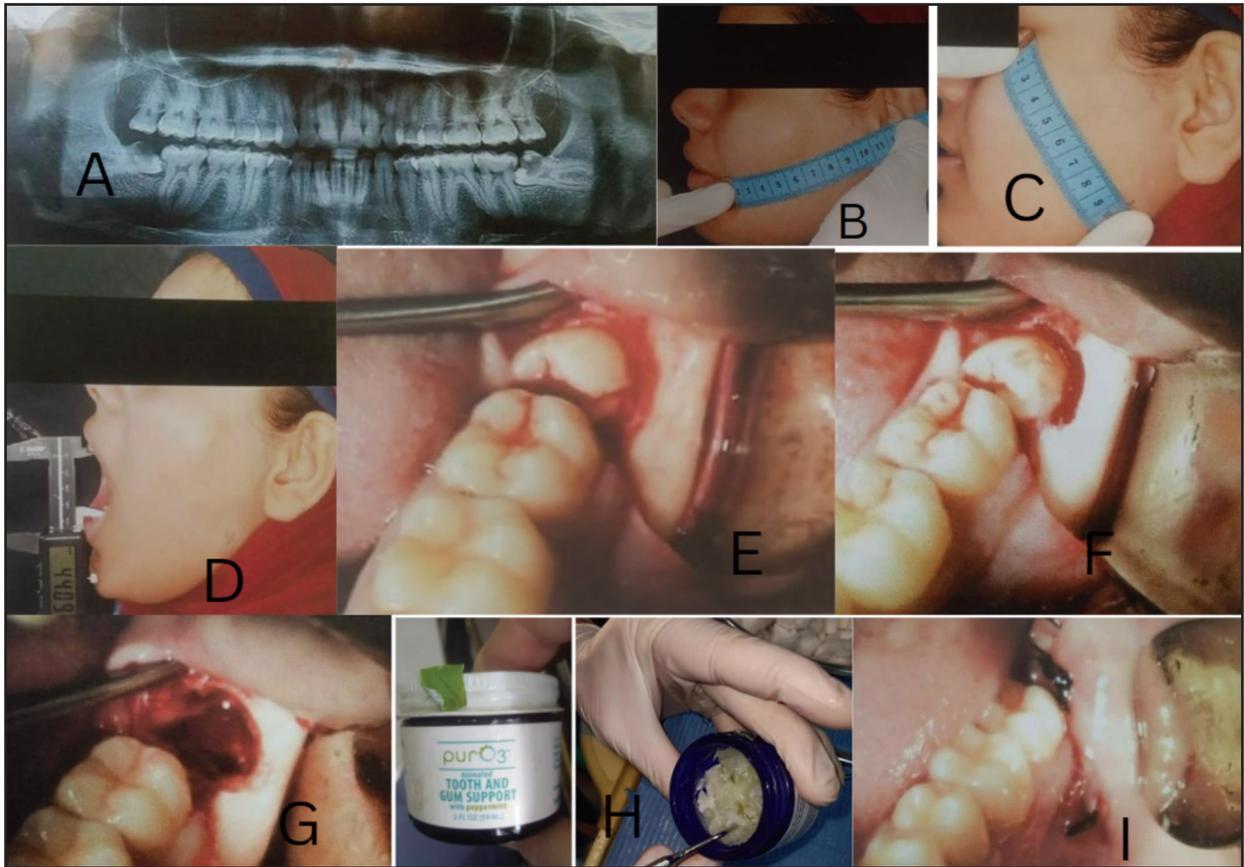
Operative procedure, (A): preoperative radiograph shows impacted teeth of the patient (B): preoperative photograph shows measurement of the distance between ear tragus and lip commissure (c): preoperative photograph shows measurement of between the distance gonion and external canthus of the eye (D): preoperative photograph shows measurement of mouths opening with digital caliper (E): photograph after reflection of mucoperiosteal flap (F) : photograph after the osteotomy.(G): photograph after the tooth delivery (H): OZONE (I): photograph after suturing.
